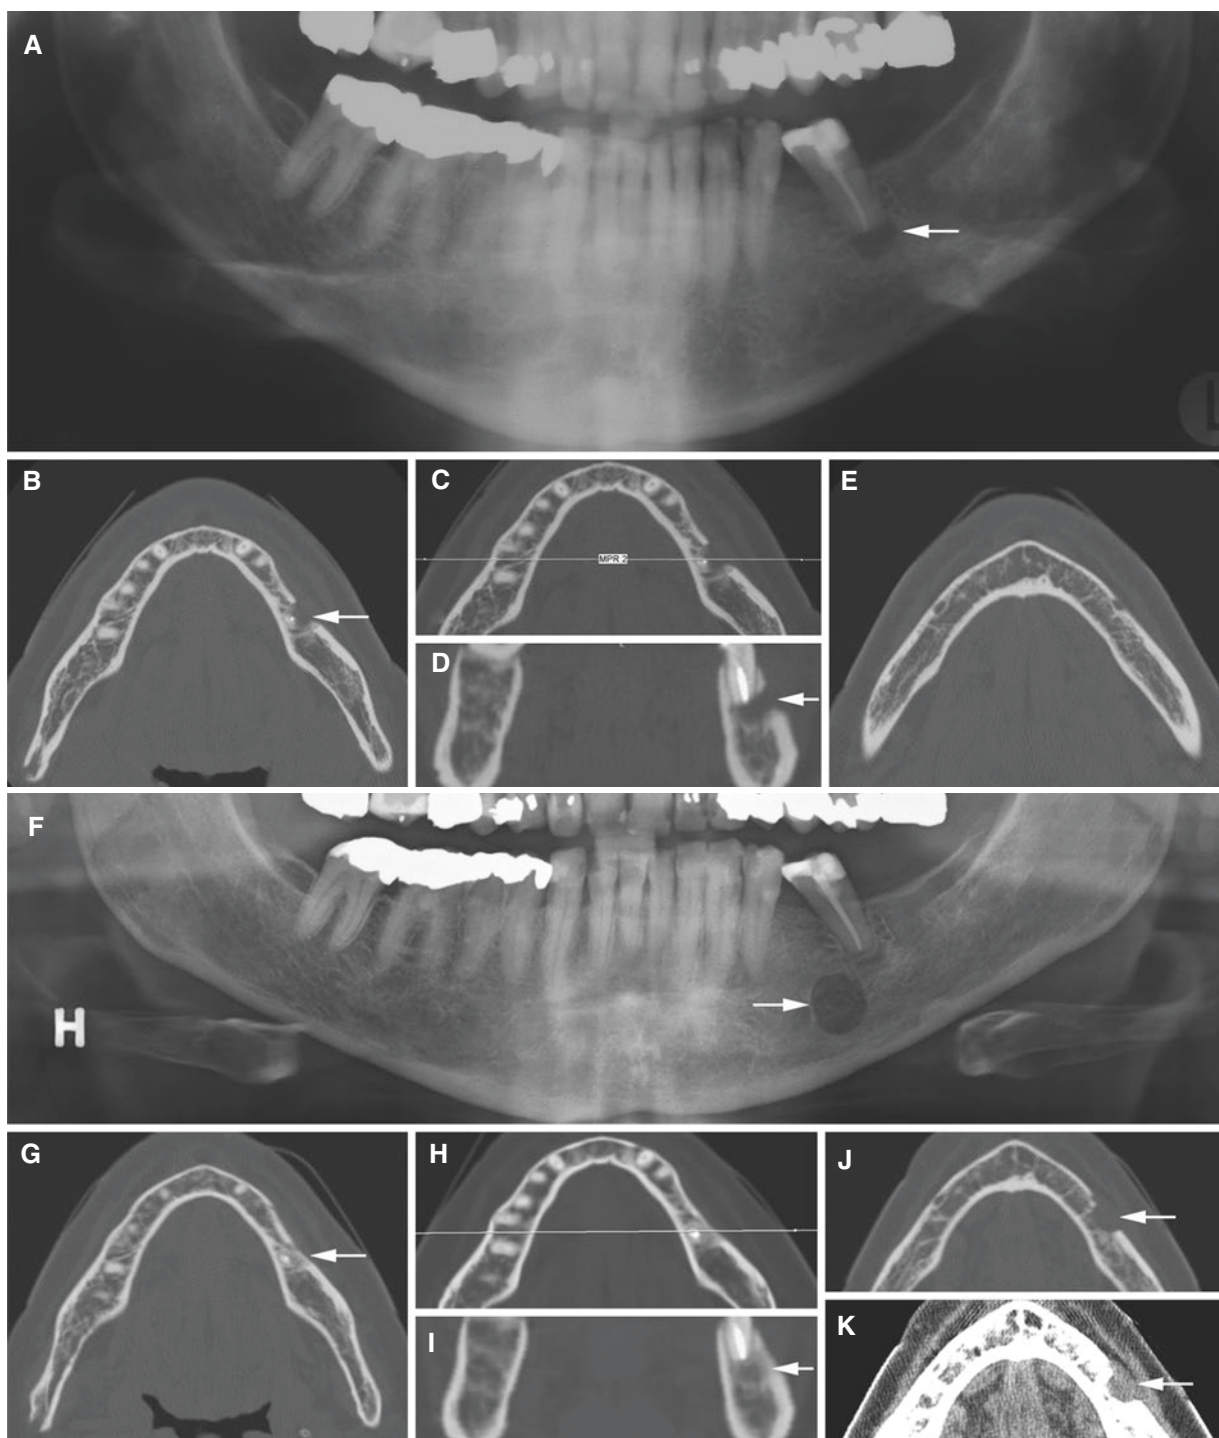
Breast cancer metastasis, mandible; 58-year-old female with some pain in the left mandible after apicectomy. (A) Panoramic view and (B) axial, (C) axial (with cursor line), and (D) coronal CT images show postoperative status after apicectomy of the second premolar (arrow). (E) Axial CT image shows normal bone structures at mental foramen level. About 1 year later, (F) panoramic view shows bone
